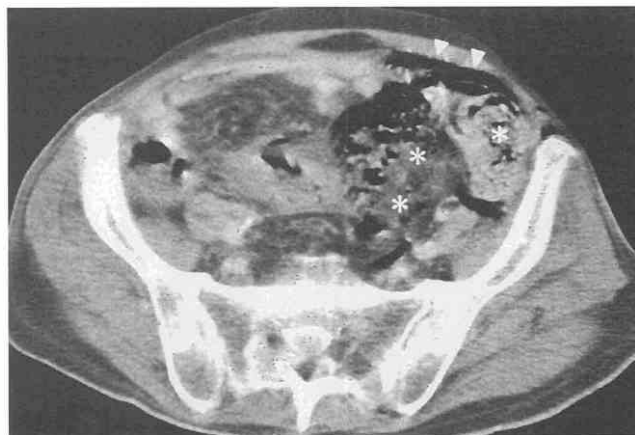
Pneumatosis in the colonic wall caused by bowel infarction. CT scan shows diffuse intramural gas in the left-sided colon (asterisks).
